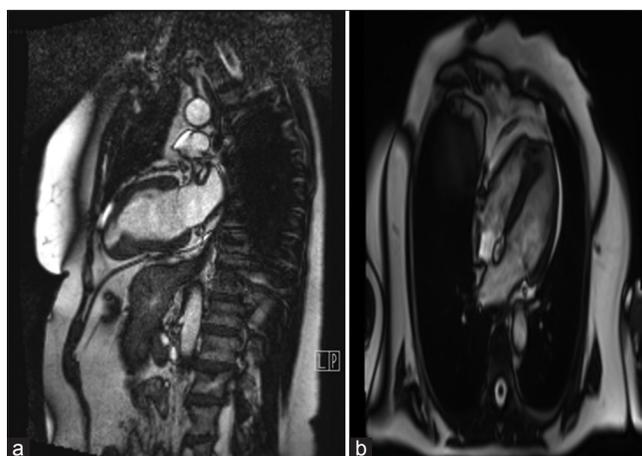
Cardiac magnetic resonance imaging: (a) Post-gadolinium early, (b) post-gadolinium with apical aneurysm, and epicardial enhancement
